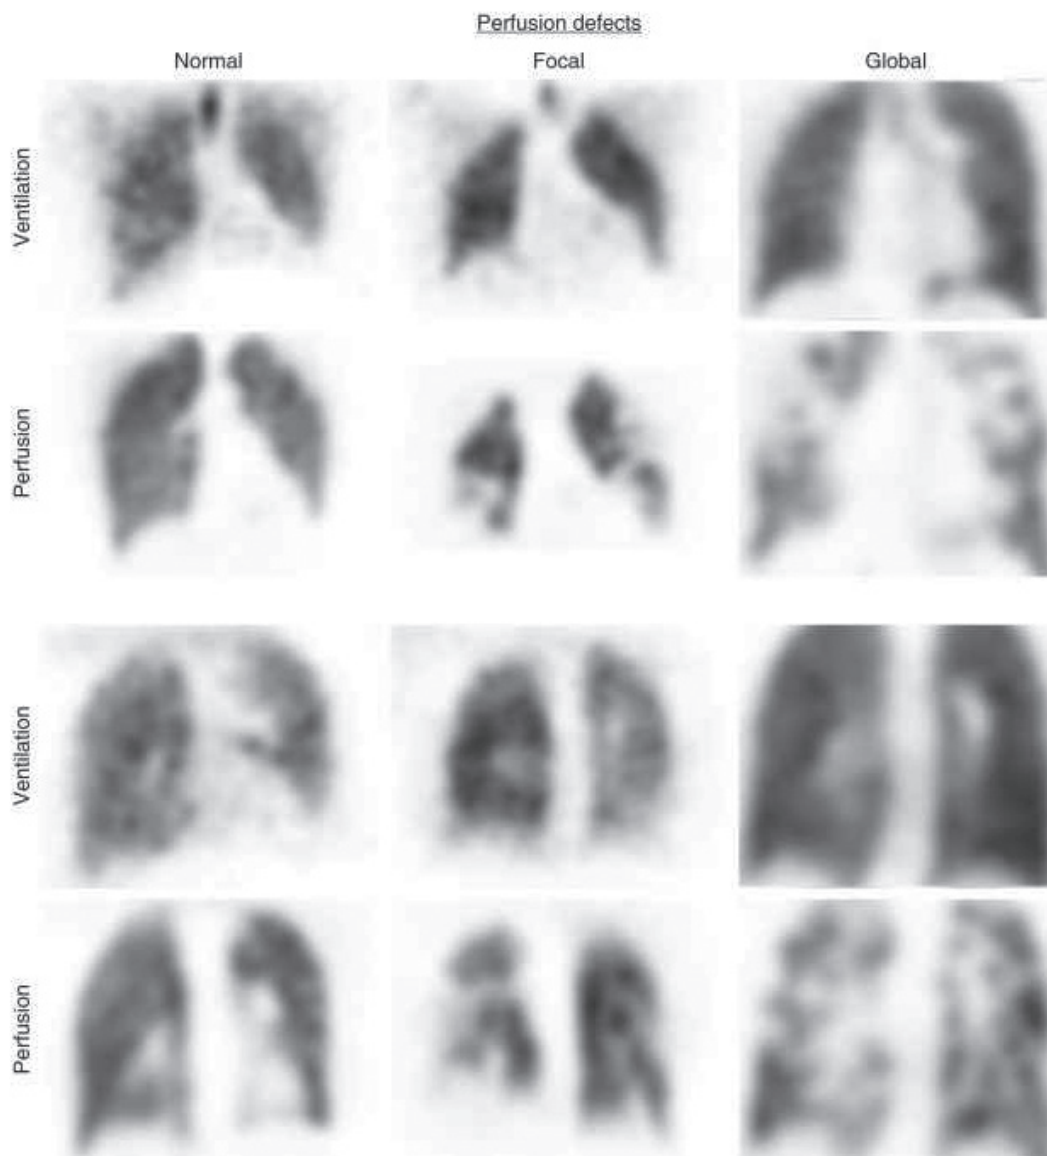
SPECT V/Q images of normal (left) and perfusion defect consistent with CTEPH in patients with supporting clinical evidence [57].
